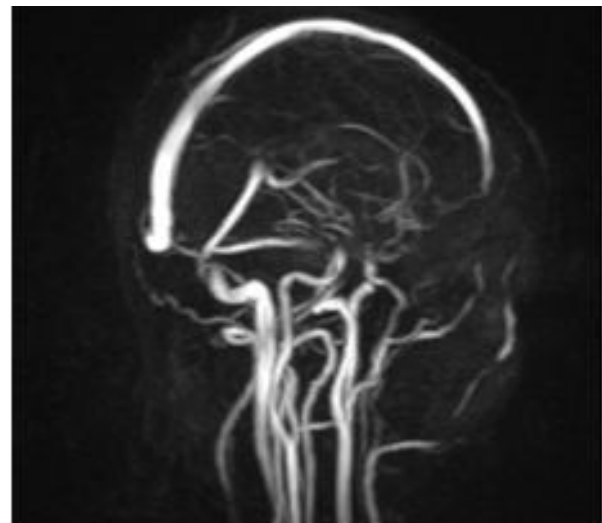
MRI showing absence of hemorrhage, infarct or cortical vein thrombosis
